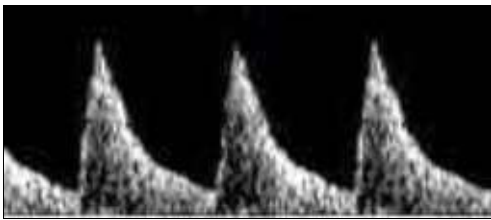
Normal flow of the middle cerebral artery in second and third trimester (Doppler in Obstetrics by The Fetal Medicine Foundation, chapter 3)
